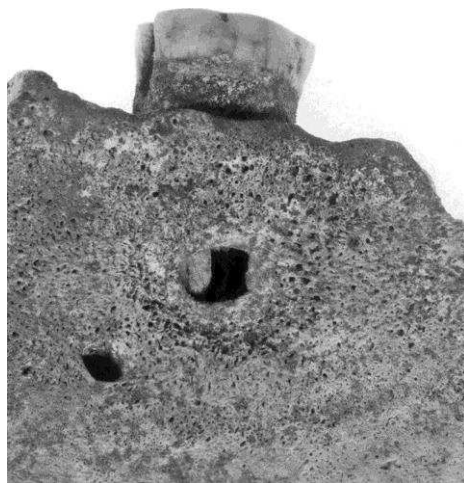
Portion of a mandible showing a periapical abscess. The root apex is visible in the opening in the bone.
